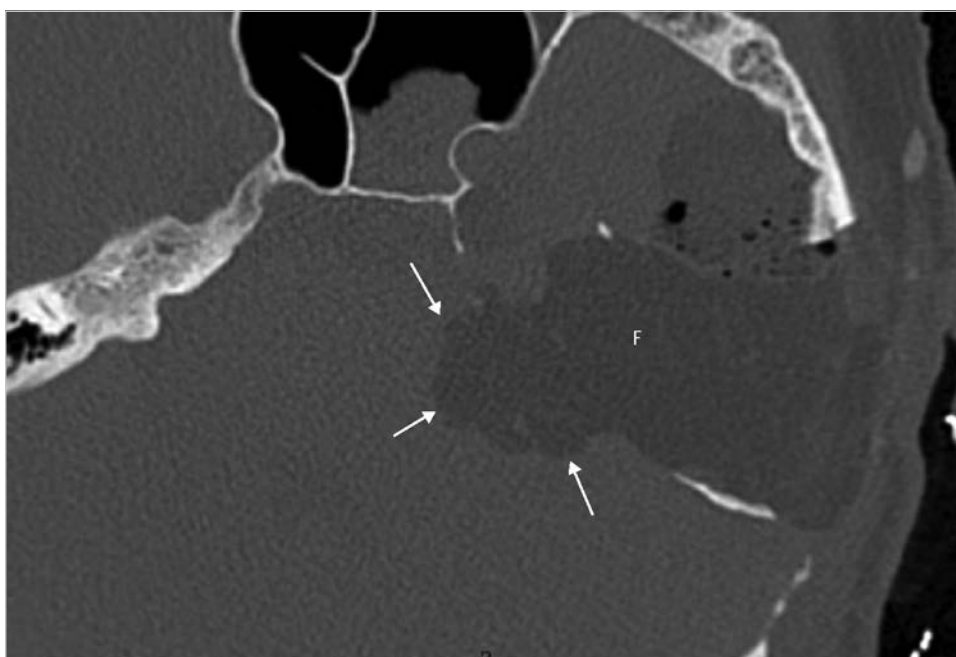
The postoperative CT immediately after the surgery shows extensive removal of the temporal bone. Note that the abdominal fat is pushed into the cerebellopontine angle (*arrows*) to tightly seal opening of the dura to avoid CSF leak. F, abdominal fat.
